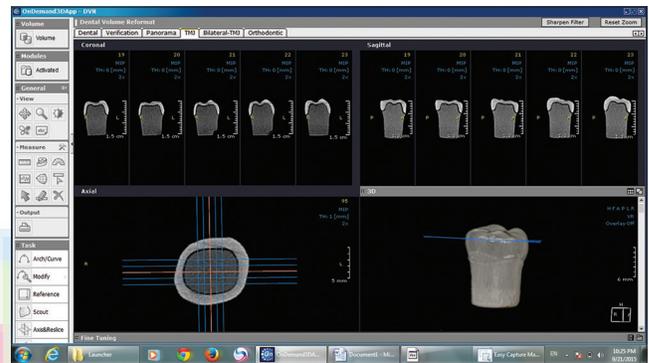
Cone-beam computerized tomography software three-dimensional, axial, sagittal, and coronal images
